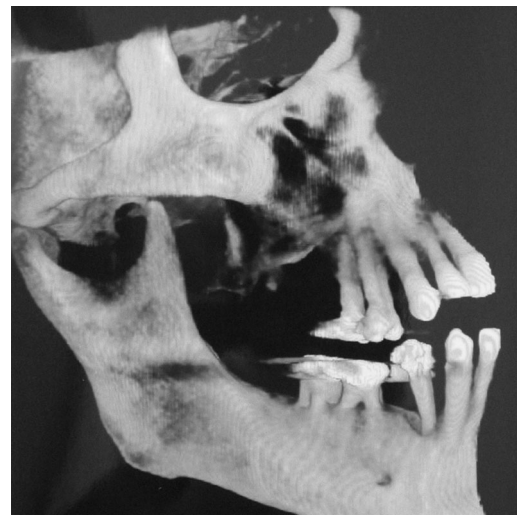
3D Reconstruction from computed tomography showing bone loss in tooth 44
